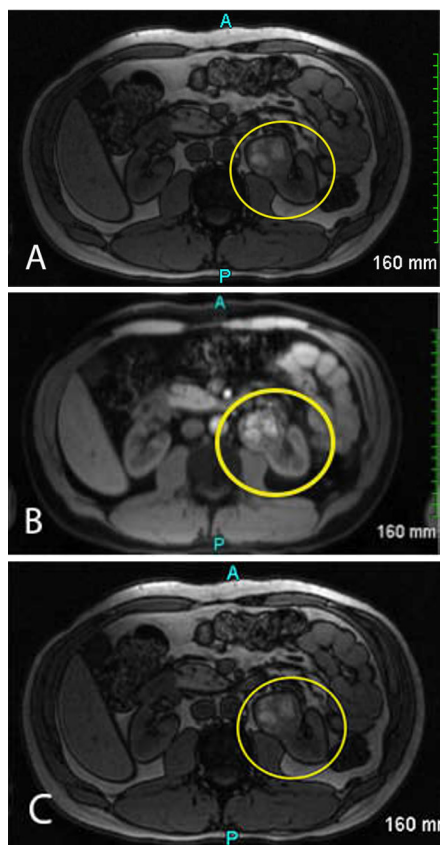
MRI axial T1 Dixon VIBE out of phase (A), T1 VIBE gadolinium-enhanced fat-saturated (B), and T1 FLASH gadolinium-enhanced fat-saturated sequences (C) showing left renal mass (circled in yellow) in a horseshoe kidney.
